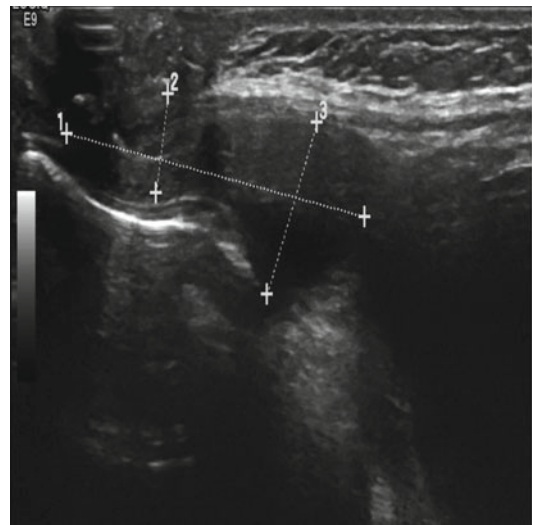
Ultrasound shows a patent urachus with at least two cystic dilations along its course
